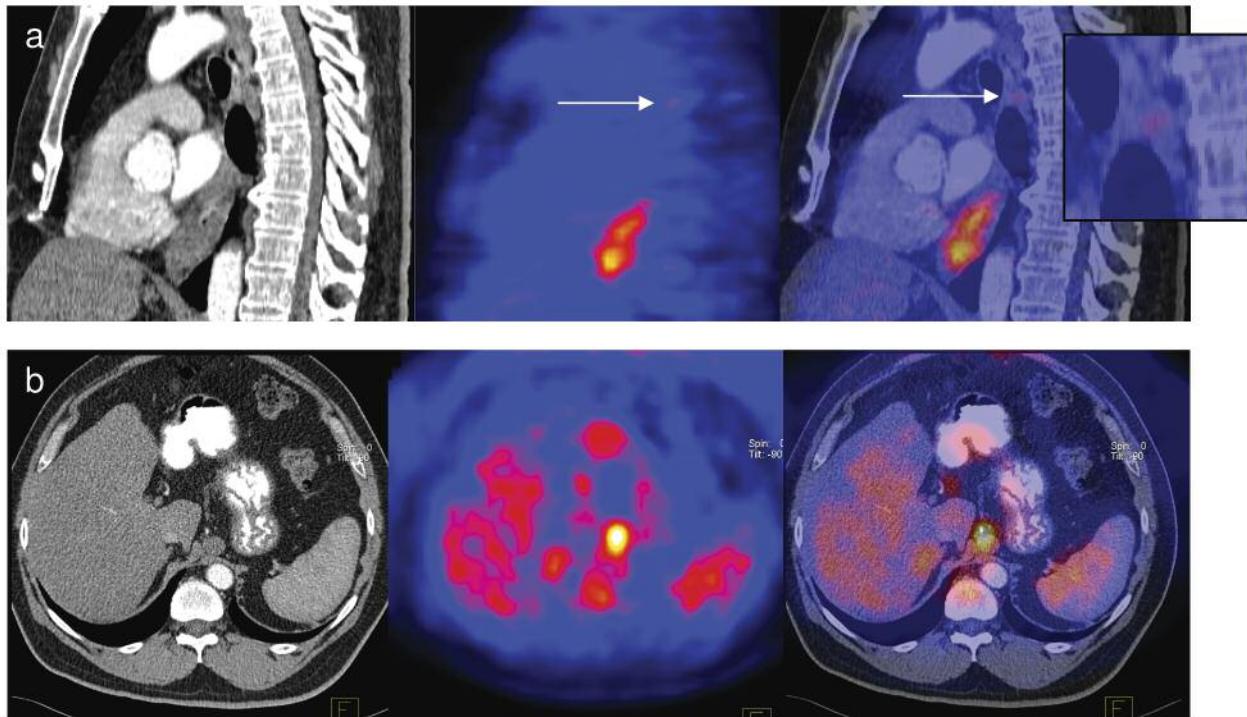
Upstaging (a) and downstaging (b). (a) Patient 15: FDG-PET, low suspicion for both nodal and skeletal metastases, but without suspicion on md-CT or EUS. Software fusion clearly showed metastatic nodal metastasis in the para-oesophageal region. Magnification shows the involved lymph node. (b) Patient 16: enlarged lymph node in the paracardial region staged as N1 on md-CT. On FDG-PET, FDG-uptake was seen in the celiac region, staged as M1a. After software PET/CT fusion both findings appeared to be the same lesion in the paracardial region.
